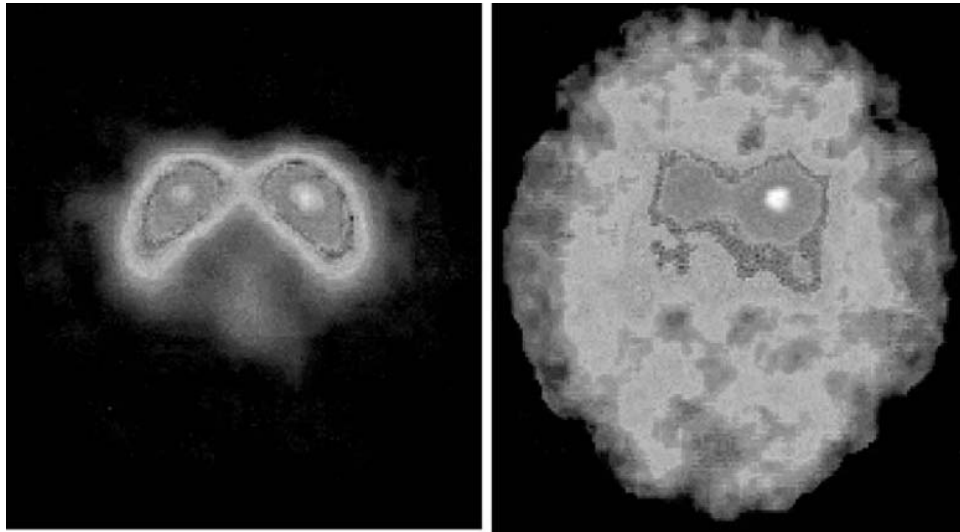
123I-b-CIT SPECT. Left: normal control (71-year-old woman). Right: 66-year-old man with PD. Courtesy of Drs. A. Varrone, J. P. Seibyl, et al. β -CIT uptake is diminished in an asymmetric way in the posterior putamen more on the right side.
